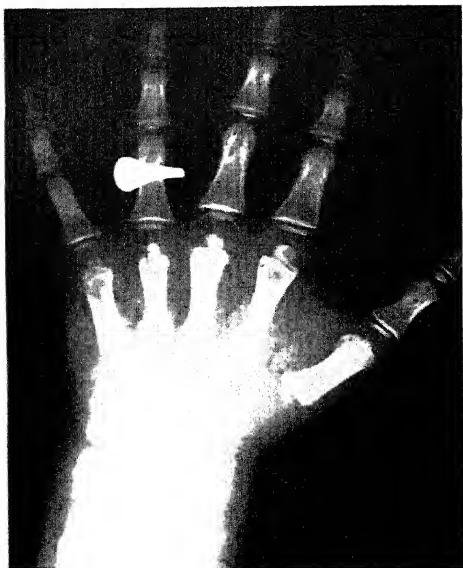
X-ray of 16-year-old wrists of a female Cretin showing a bone age of 9½ years. Note undeveloped, small, centers of ossification in the wrist as compared with normal Figure 4B.
